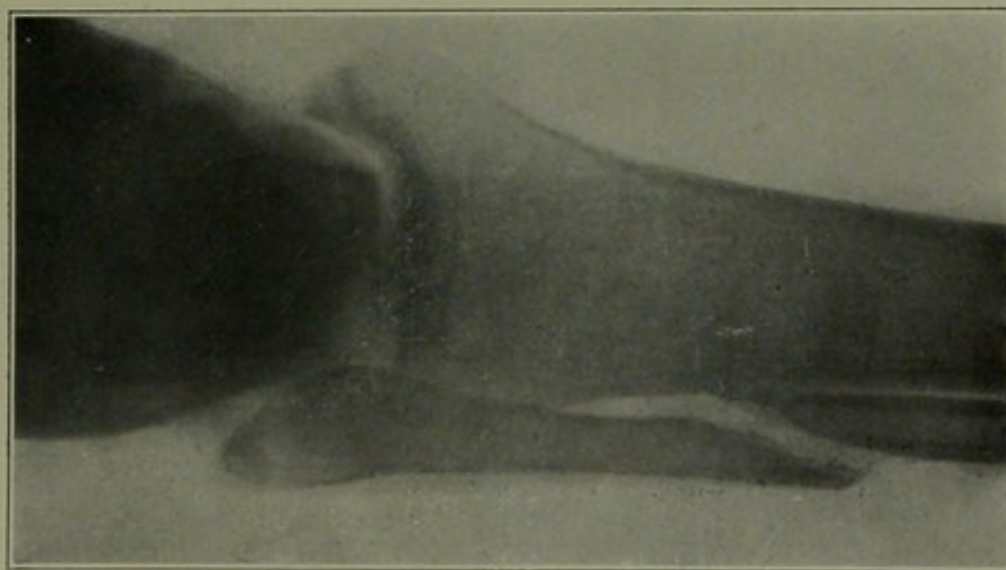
H. W., 121107. Fracture of fibula by direct violence. Presumed to be in good position. This separation could only be discovered by the X-ray. The outward displacement of the lower fragment can be corrected by eversion of the foot and a little pressure. The inward displacement of the upper fragment is incorrigible except by operation.
